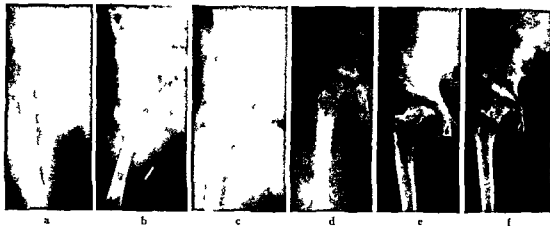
L. C. Arthroplasty for residual suppurative arthritis with dislocation in child aged 1½ years. At operation the acetabulum was deepened exposing bone. The end of the femoral neck was trimmed. The trochanter was braced outward from the neck ¼ inch and supported in position by a bone transplant. Motion was begun in 6 weeks. The series of roentgenograms shows the joint changes that occurred over a period of 5 years. Before operation the patient was free from pain but dislocation
